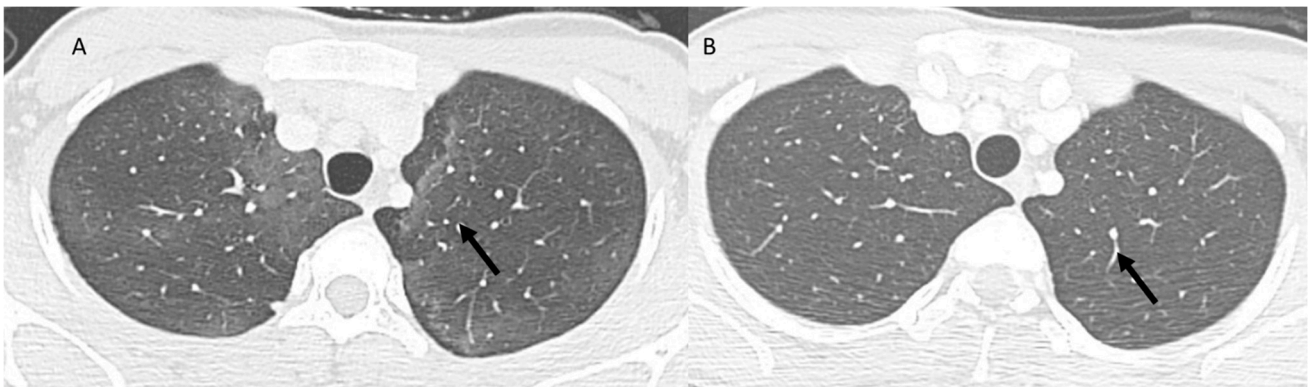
CT assessment (A) of CIP: OP pattern with peribronchovascular and subpleural distribution bilaterally of ground-glass opacities (arrow). Resolution of pneumonitis (B) after steroids (arrow) treatment.
